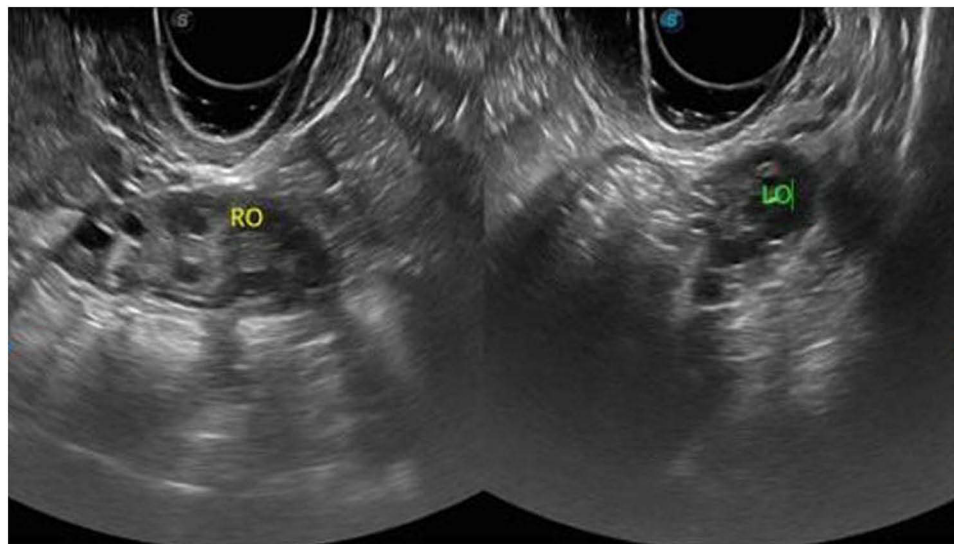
Follow-up transvaginal ultrasound of the right ovary after methotrexate treatment showing regression and complete resolution of the previously identified ovarian gestational sac, with no persistent gestational structure seen on follow-up imaging. Notes: Letters denote the labeled structures or key findings, and yellow lines highlight the relevant boundary or area of interest.
